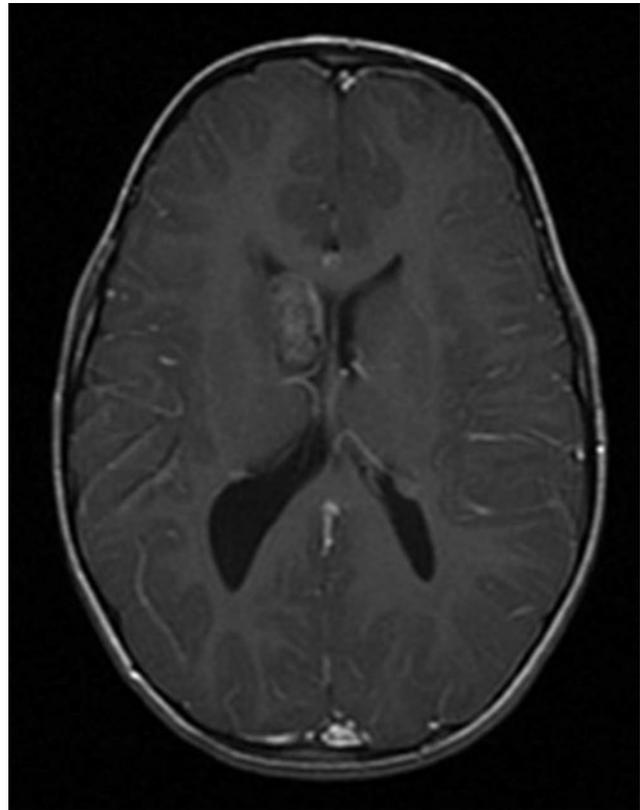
Magnetic resonance imaging of the brain of a 4-year-old girl with tuberous sclerosis complex. This axial T1-with-contrast sequence demonstrates a subependymal giant cell astrocytoma, which is an enhancing, noncalcified lesion near the foramen of Monro.
